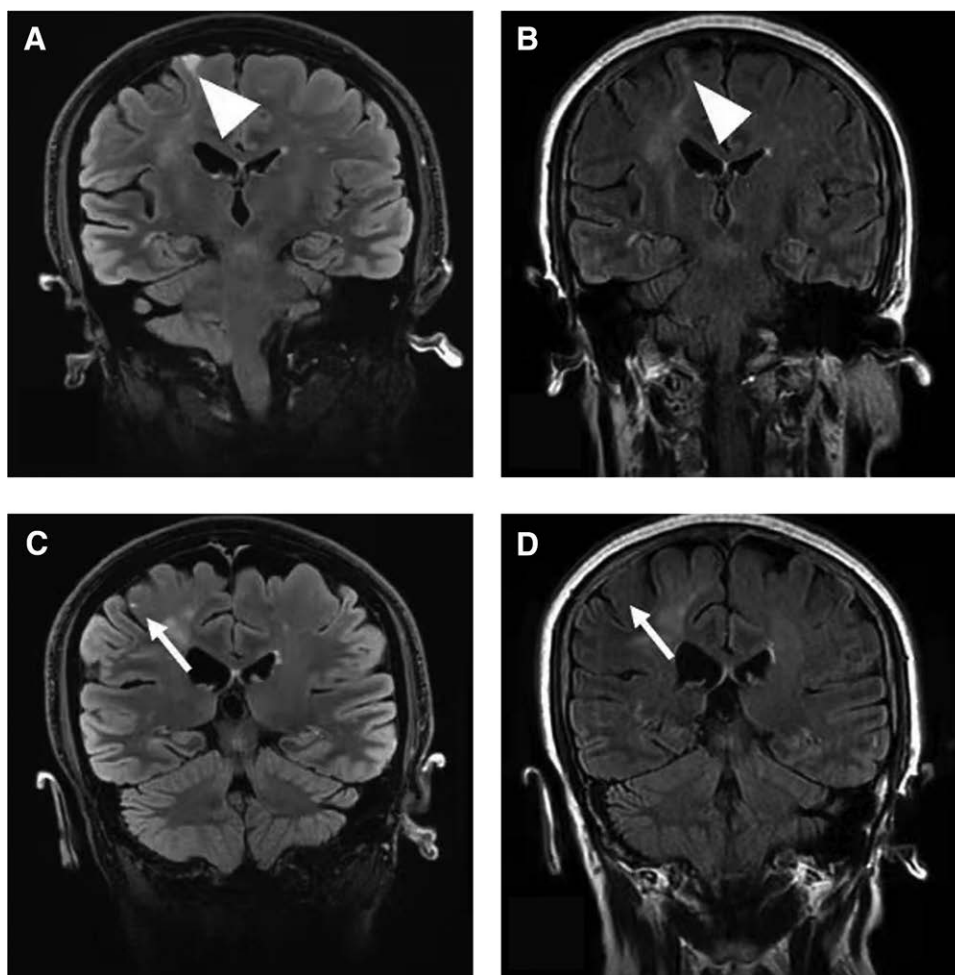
Detected CMIs. CMI was detected by 3D Cube FLAIR plus HyperSense (A), while was not identified by 2D T2WI FLAIR (B) in a patient. Similarly, CMI was detected by 3D Cube FLAIR plus HyperSense (C), while was not identified by 2D T2WI FLAIR (D) in another patient. These indicated 3D Cube FLAIR plus HyperSense was more sensitive to detect CMIs. 2D = 2-dimension, 3D = 3-dimension, CMI = cortical microinfarct.
